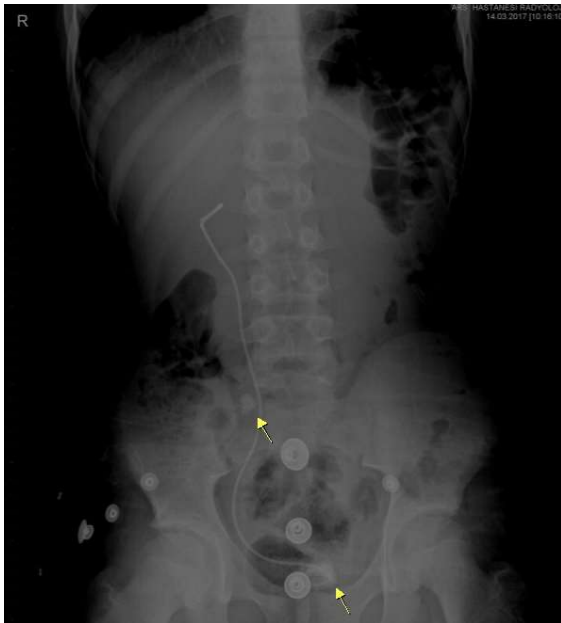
Renal, ureteric and bladder (KUB) radiograph view of the stone burden and encrusted double-J stent.
